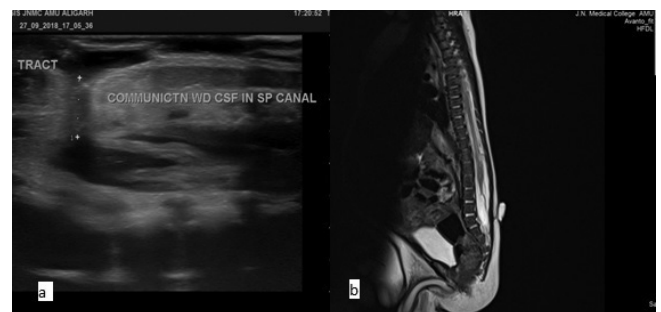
Sagittal high resolution USG image at L5 level of spine shows anechoic CSF containing sac with small communication with spinal canal via defect in posterior element of L5 suggestive of posterior meningocele .T2 weighted sagittal MRI spine in the same patient confirming the findings of USG.
